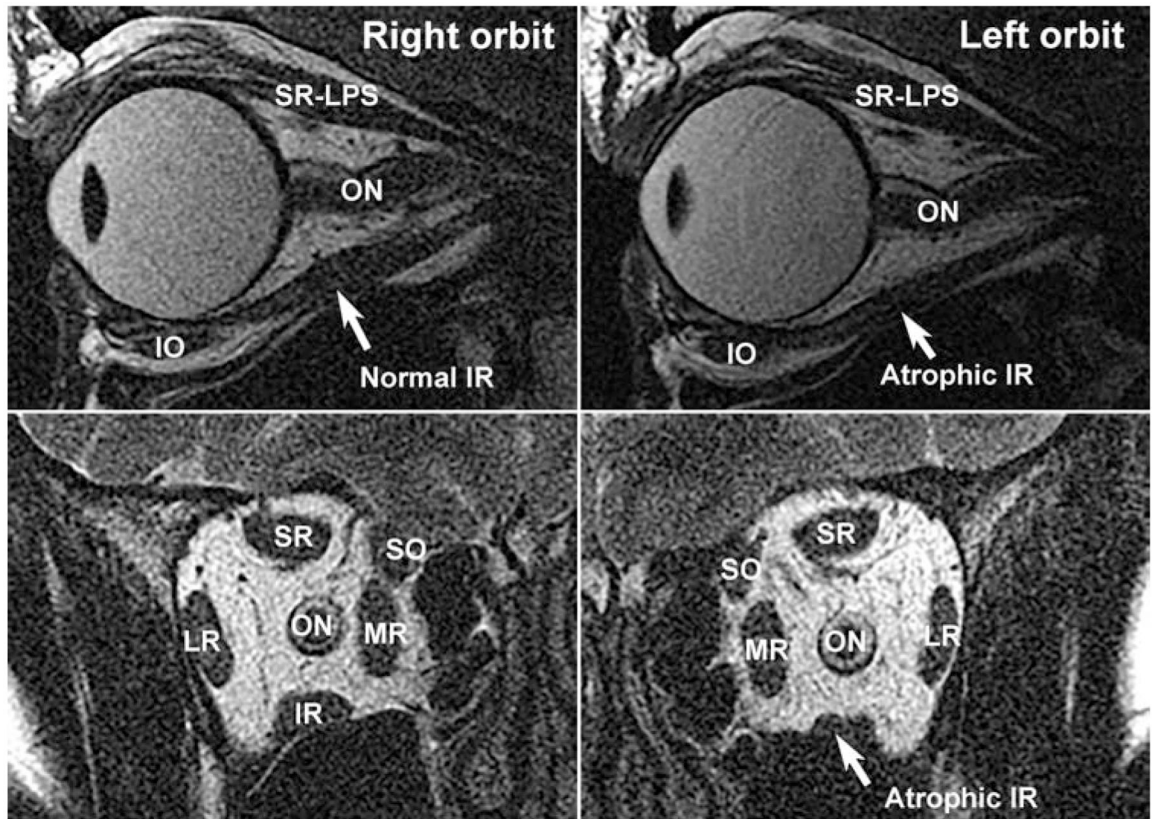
Case 4. Sagittal (top row) and coronal (bottom row) MRI of right (left column) and left (right column) orbits in central gaze, demonstrating atrophic left IR with inferior bowing.
